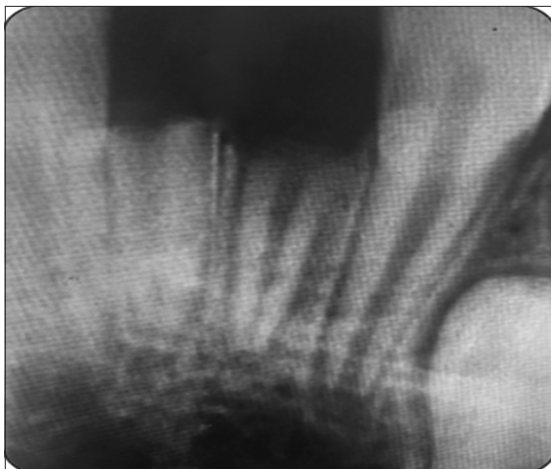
Pre-operative radiographic view
